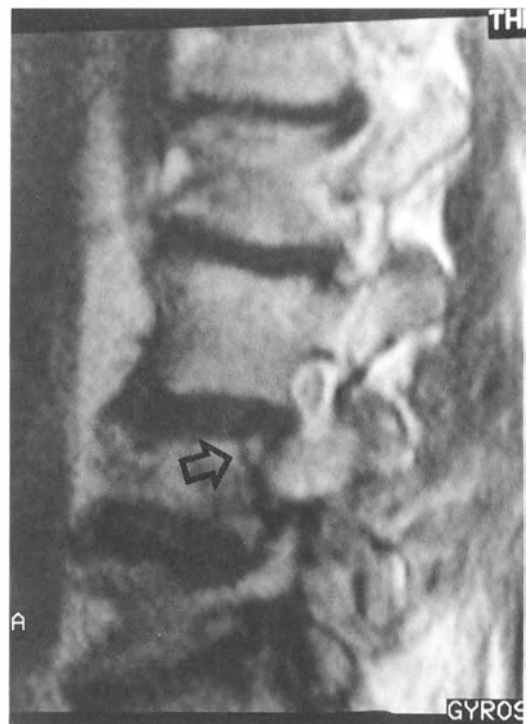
A. The plain lateral lumbar x-ray study before surgery. Note the vacuum changes within the discs and the marked advanced degenerative disc disease and retrolisthesis subluxation of L4 on L5. B. The first surgical postoperative magnetic resonance image showing the hyperintense area within the vertebral canal (*arrow*) representing Gelfoam from surgical placement. At the *open arrow* is shown the persistent posterior displacement of L4 on L5 with a disc bulge (*curve arrow*). This is instability of L4 on L5.
